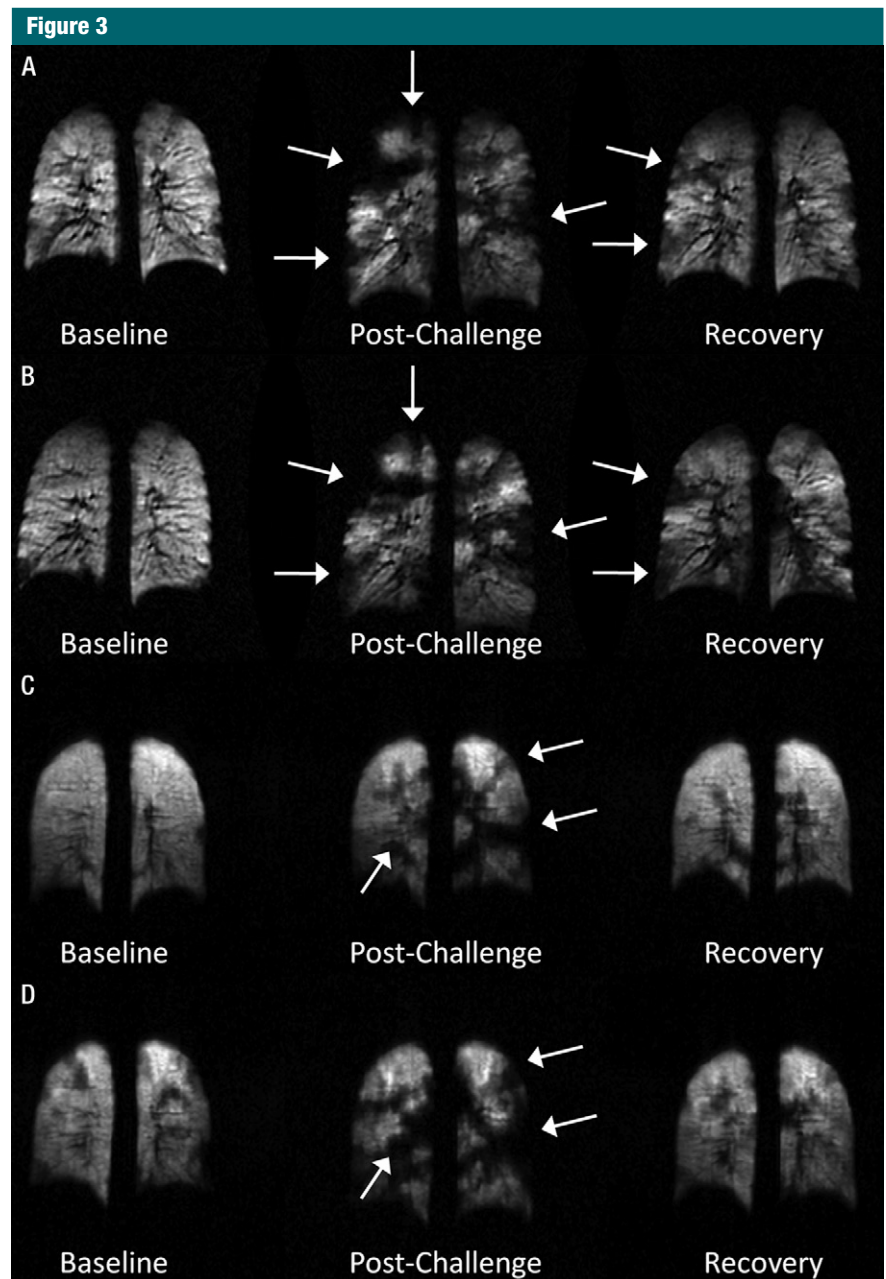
Typical coronal HPHe MR images acquired at baseline (left), postchallenge (middle), and recovery (right) time points for one patient on the A, first and B, second visits at site A and one patient on the C, first and D, second visits at site B. Defects (arrows) appear with similar size and location during each visit.
